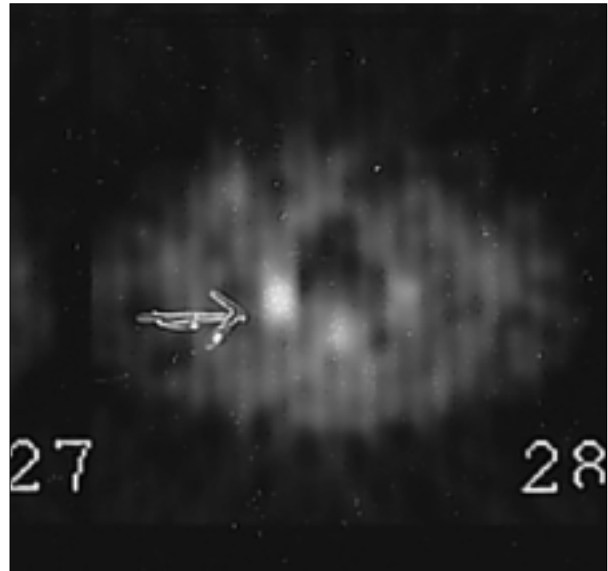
B. ^{99m}Tc -Depreotide study shows an area of increased uptake, which correlates, with the position of the 2 cm nodule noted on CT. Also, there is some increased activity at the right hilum. Recommendation is for percutaneous biopsy. Reprinted courtesy of St. Joseph's Hospital, Elmira, NY.
